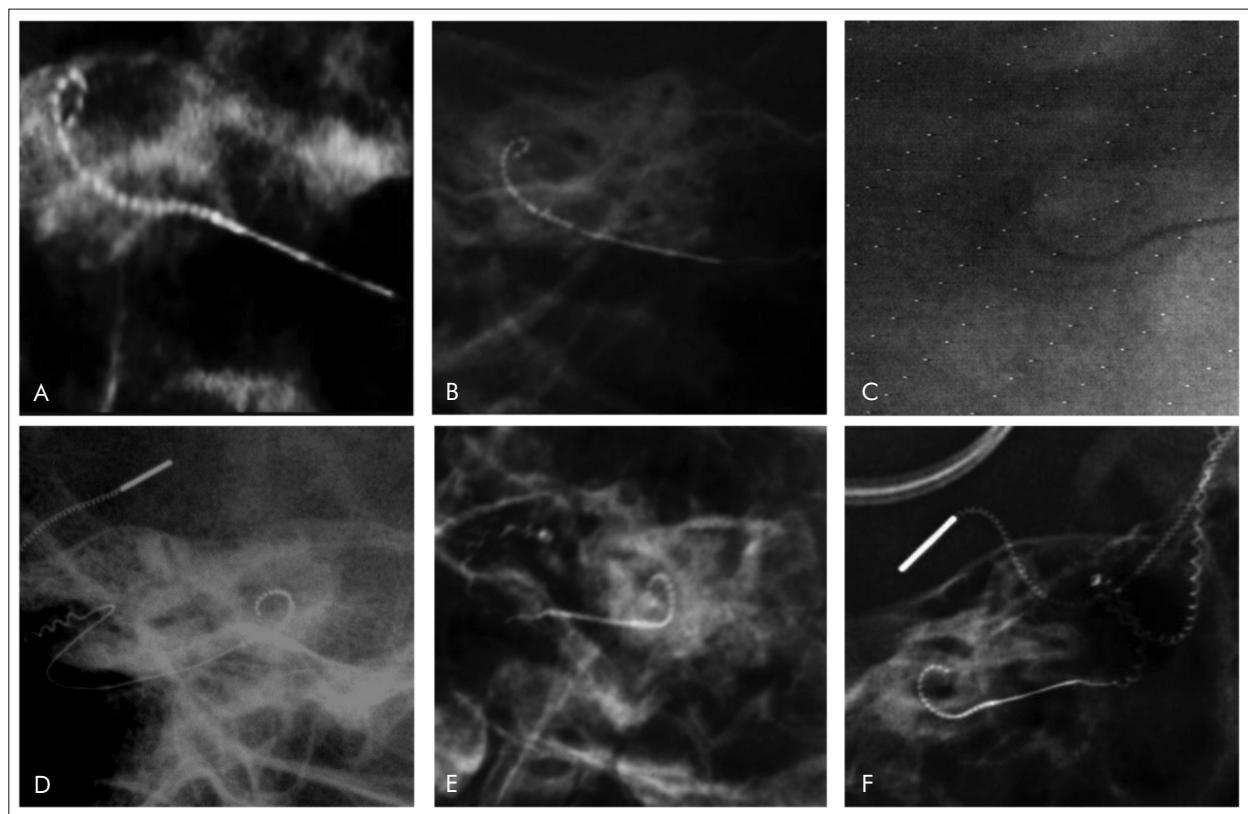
Radiography of the three cases. A Subject #1, postoperative radiography, Stenvers view. B Subject #2, postoperative radiography, Stenvers view. C Subject #3, postoperative fluoroscopy, cochlear view. D Subject #1, postoperative radiography after revision surgery, Stenvers view. E Subject #2, postoperative radiography after revision surgery, Stenvers view. F Subject #3, postoperative radiography after revision surgery, Stenvers view
